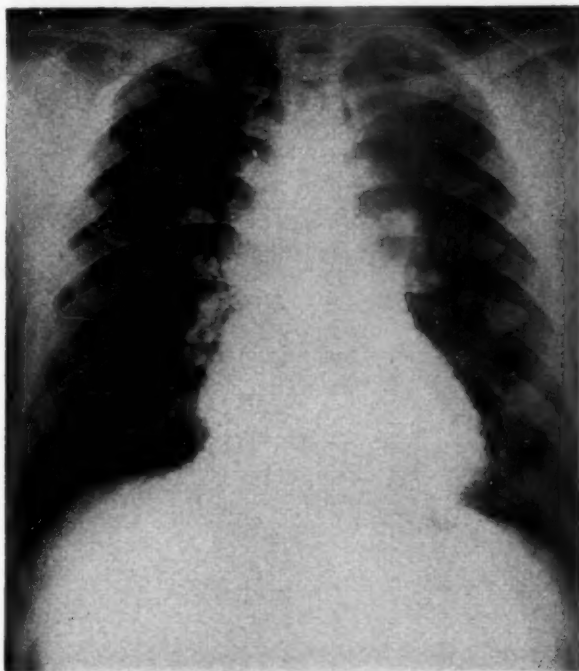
Chest roentgenogram demonstrating the large ovoid shadow in the superior mediastinum which forms a "figure-of-8" appearance with the heart.
